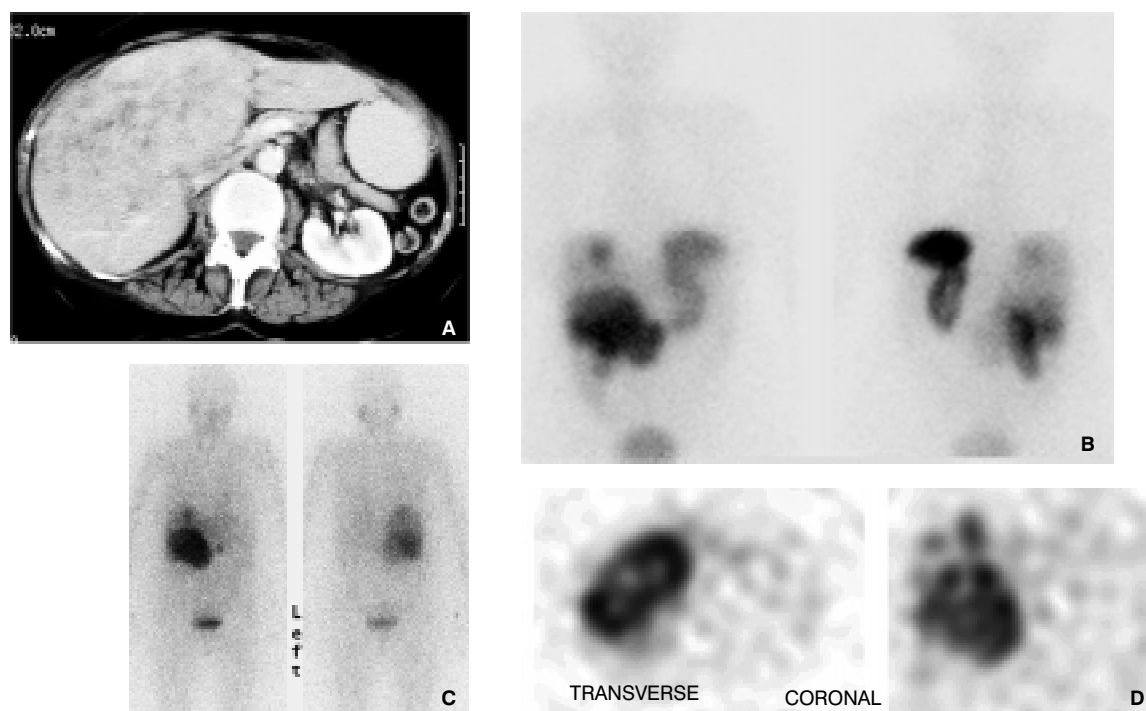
Metastatic carcinoid tumour, at 70-year-old man with primary carcinoid of the caecum, currently with liver deposits. A. Triple phase CT with contrast enhancement (10 mm section) shows extensive mass extending from the inferior aspect of segment VIII down into segments V and VI completely replaced and 2 smaller deposits in segment VIII. This huge mass enhances to the same degree as liver parenchyma apart from central areas of presumable necrosis. B. Whole Body (WB) In-111 Octrotide scan shows the same distribution of tracer within huge right lobe mass and additional 2 small in segment VIII. C. and D. WB and SPECT (transverse and coronal) I-123 mIBG images show similar pattern of distribution of radiotracer, additional SPECT shows central part of the tumour with low uptake indicated central part necrosis.
